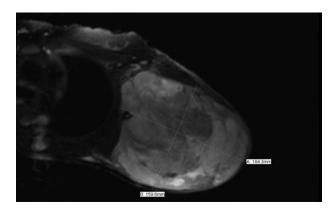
Magnetic resonance imaging of left shoulder, Mass: 18.4 cm \times 15.9 cm \times 20 cm.
